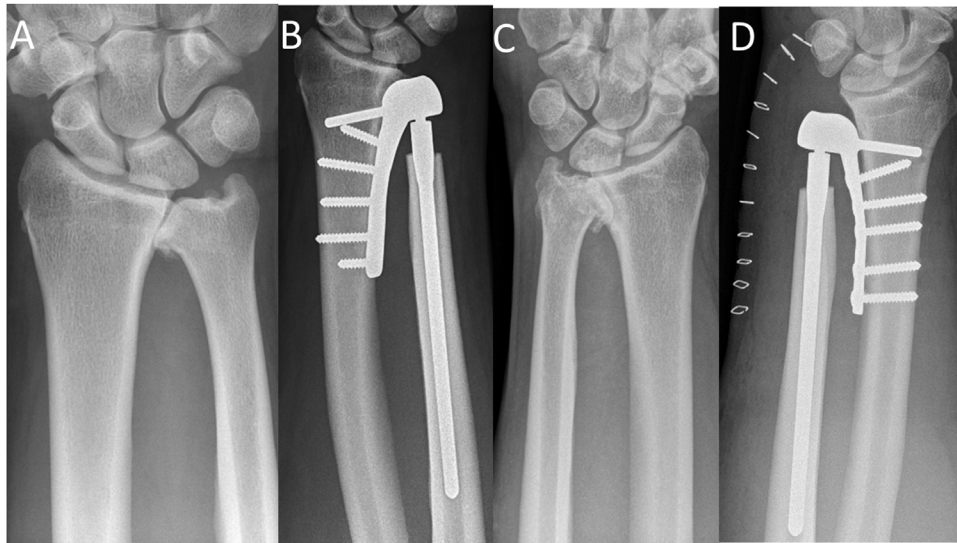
Patient 2. Preoperative PA X-ray of the left wrist (A). Postoperative PA X-ray of the left wrist (B). Preoperative PA X-ray of the right wrist (C). Postoperative PA X-ray of the right wrist (D).
